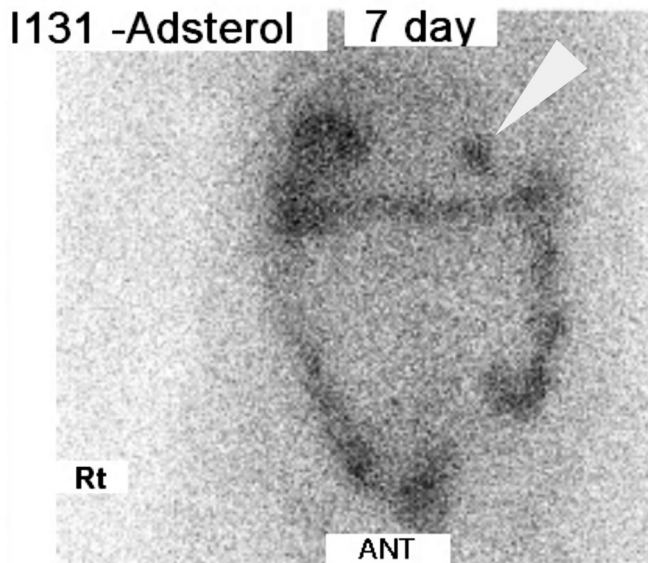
Adrenal scintigraphy with ¹³¹I-adsterol (anterior-posterior view) shows significant accumulation in the left adrenal gland. The white arrow head indicates.
